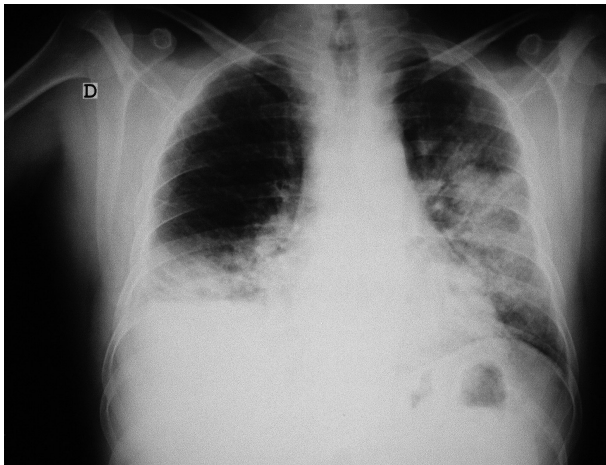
Chest radiograph in which we see a consolidation right basal pleural effusion and an interstitial pattern alveolar in the left lung.
